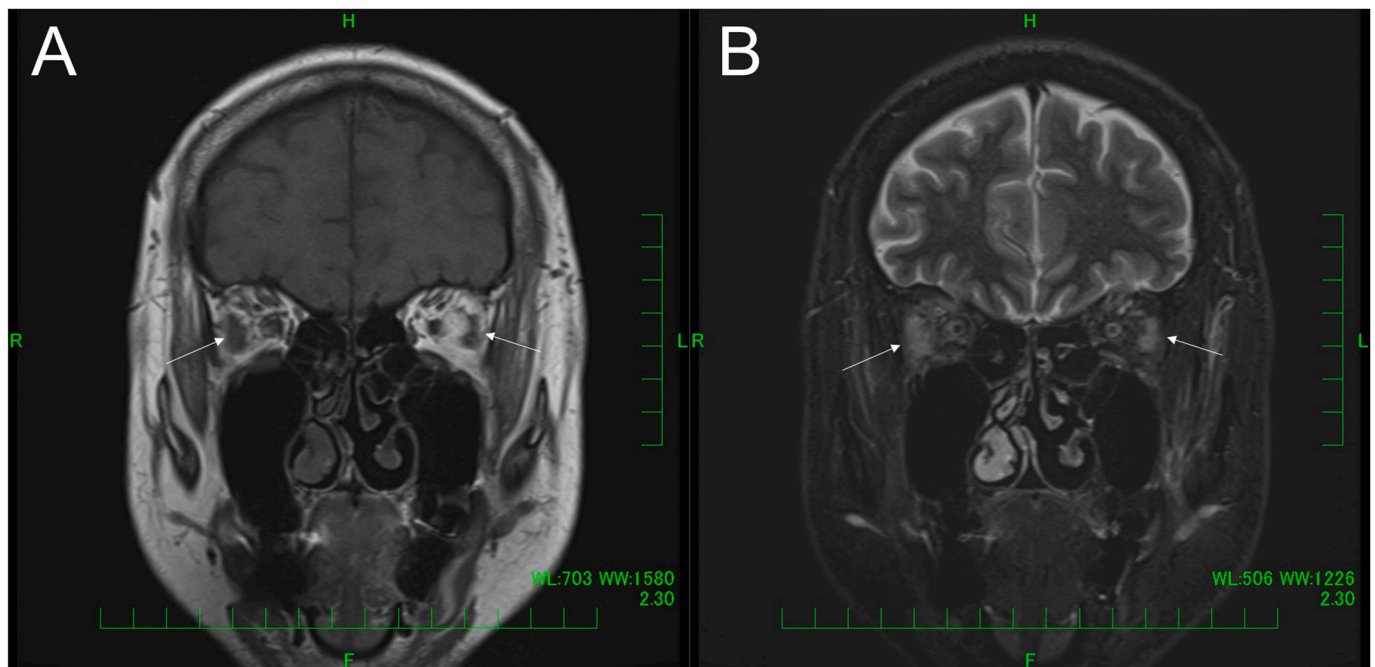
Magnetic resonance imaging of the head shows slight enlargement of the bilateral lateral rectus muscles (A, arrows), particularly the lateral rectus muscle of the right eye. Short tau inversion recovery shows a slightly high signal in the lateral rectus muscles of both eyes (B, arrows).
